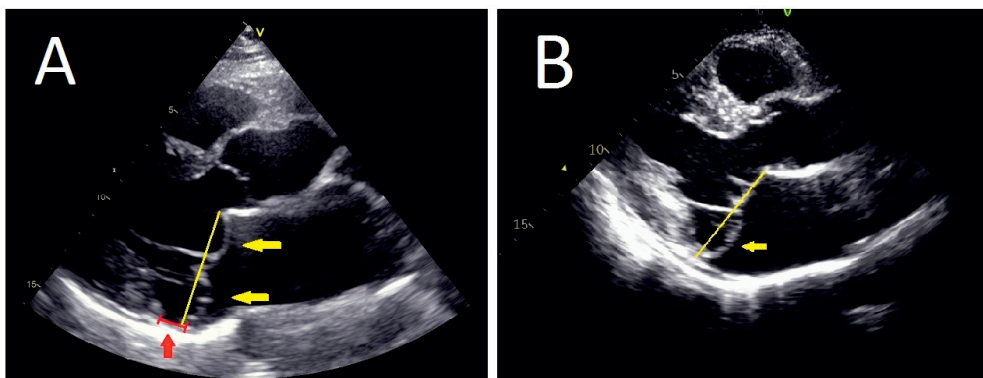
Transthoracic echocardiographic images of parasternal long-axis view of the mitral valve (MV). Panel A shows bi-leaflet MV prolapse (yellow arrows) and significant mitral annular disjunction (red arrow) in a patient
